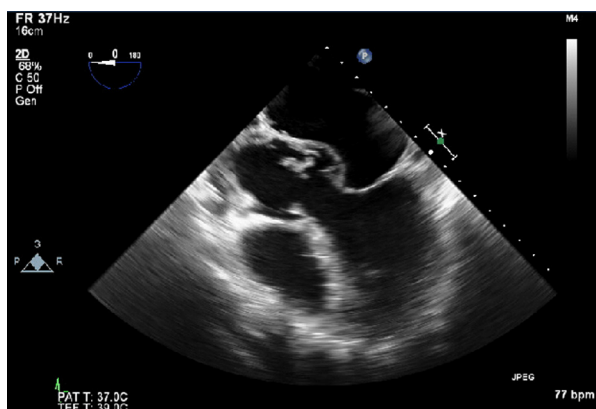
Midesophageal 5-chamber transesophageal echocardiography image.
